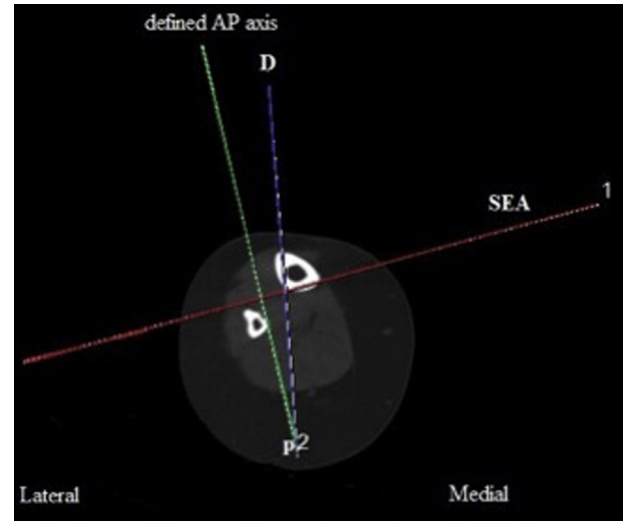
Axial CT image at mid-tibial level in which angle D is the angle between the AP axis and the line connecting the most prominent point on the anterior border of tibia to PCL.
